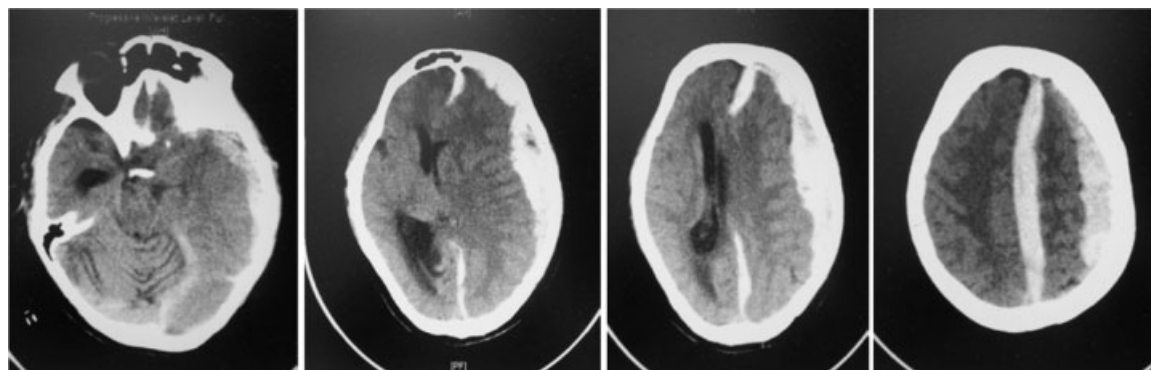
Preoperative noncontrast CT scan showing extent of acute subdural hematoma of thickness 2.5 cm over left frontoparietal region causing severe subfalcine herniation leading to compression of ipsilateral lateral ventricle and transtentorial herniation producing severe mass effect and midline shift and associated inter-hemispheric fissure acute subdural hematoma.
